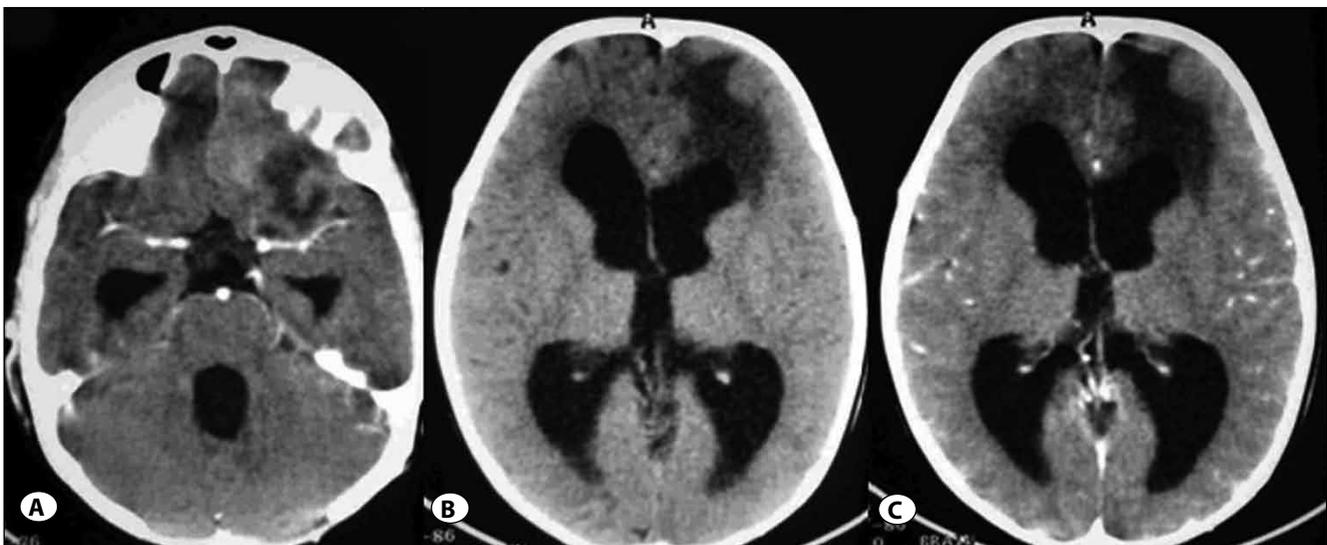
CT with images of case No.3 after 6 months (Case No.3). Note the absence of any residual or recurrent lesions in the fourth ventricle (A). A non-enhancing left frontal mass is seen along with tetra-ventricular hydrocephalus (B and C).
